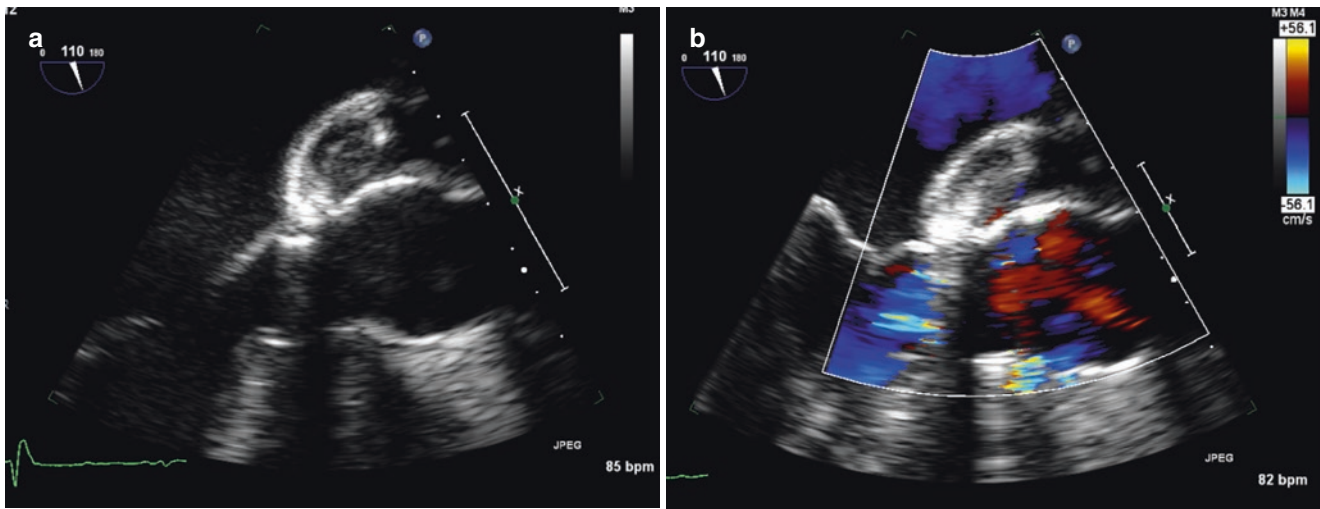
TEE (a) short-axis and (b) long-axis images showing aortic root abscess formation (arrows) in a patient with aortic valve endocarditis. (TEE Transesophageal echocardiogram). From Shah T:
